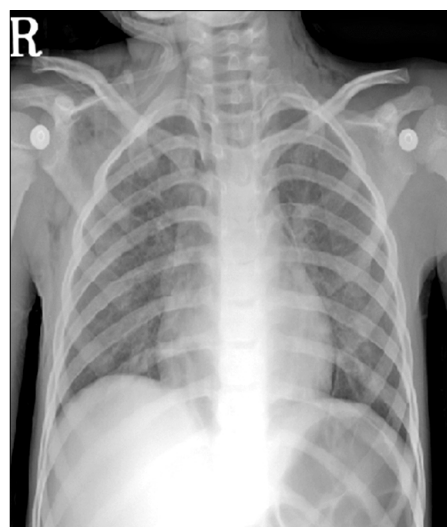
Chest X-ray obtained on the day of discharge. Consolidation of the left upper lung zone was resolved. R, right.
